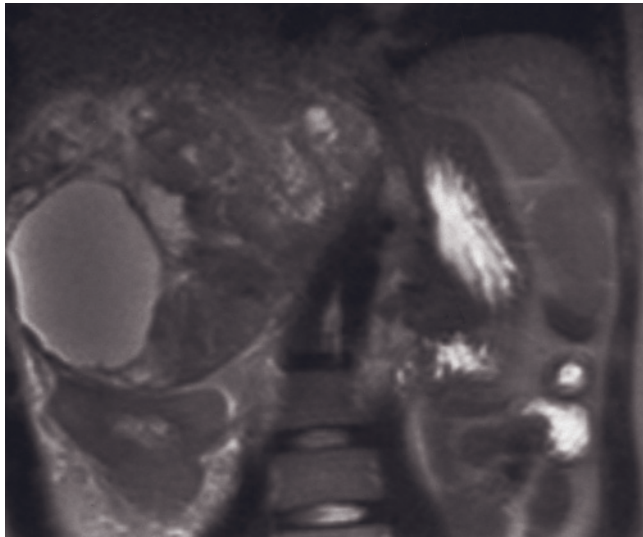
(Continued) The tumor abuts on the right kidney. Transverse T2-weighted single-shot echo-train spin-echo (g), coronal (h) and transverse (i) T1-weighted spin-echo, and transverse postgadolinium interstitial-phase spin-echo (j) images demonstrate right adrenal neuroblastoma. The lesion contains hemorrhage, which shows high signal on T1-weighted images (b, i). The lesion shows enhancement on postgadolinium image (j).
